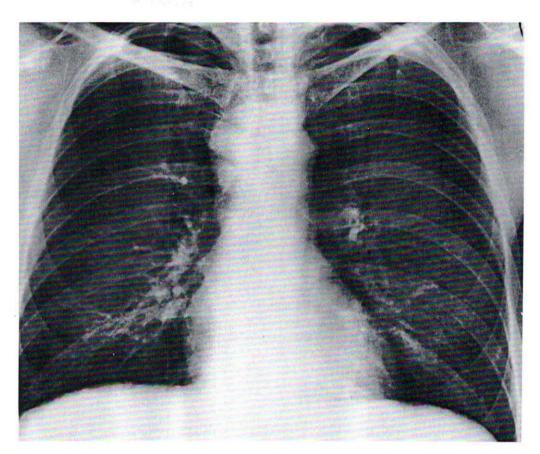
Frontal view, chest radiograph, showing right paratracheal adenopathy as a manifestation of recently acquired tuberculous infection.
